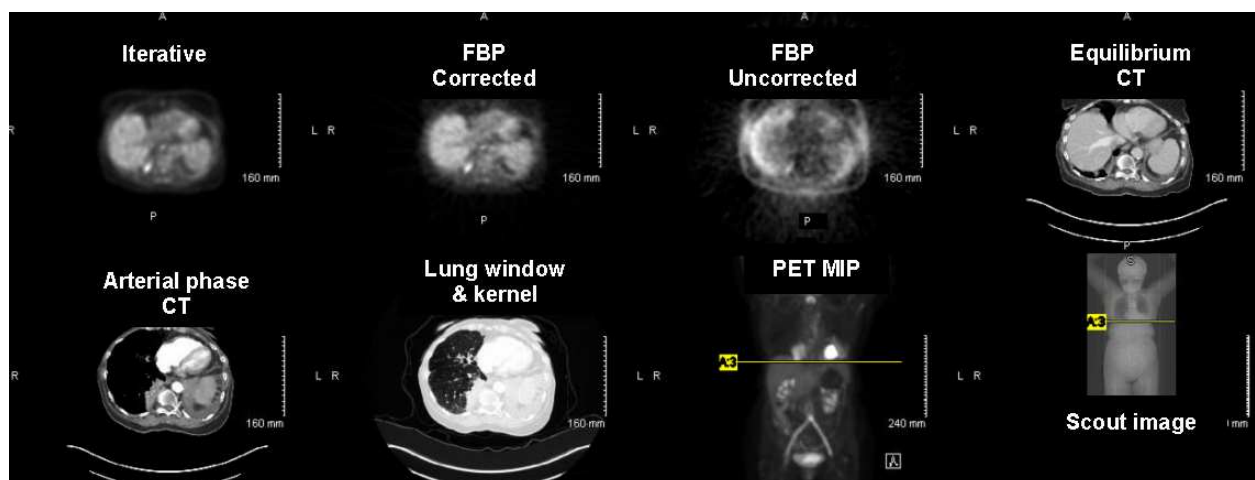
Typical transaxial PET-CT image reconstructions. Note CT was acquired with both arterial and equilibrium contrast phases and rendered in multiple kernels and windows
